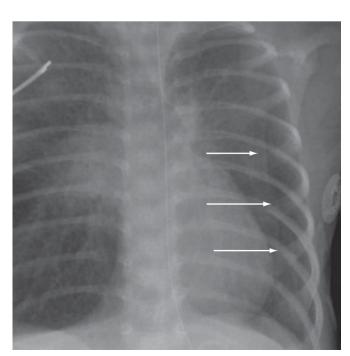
Skinfold mimicking a pneumothorax. Radiograph in a 26-dayold girl demonstrates an interface (*arrows*) in the left hemithorax. Lung markings are seen peripheral to the interface, and a subsequent radiograph did not show signs of a pneumothorax.
